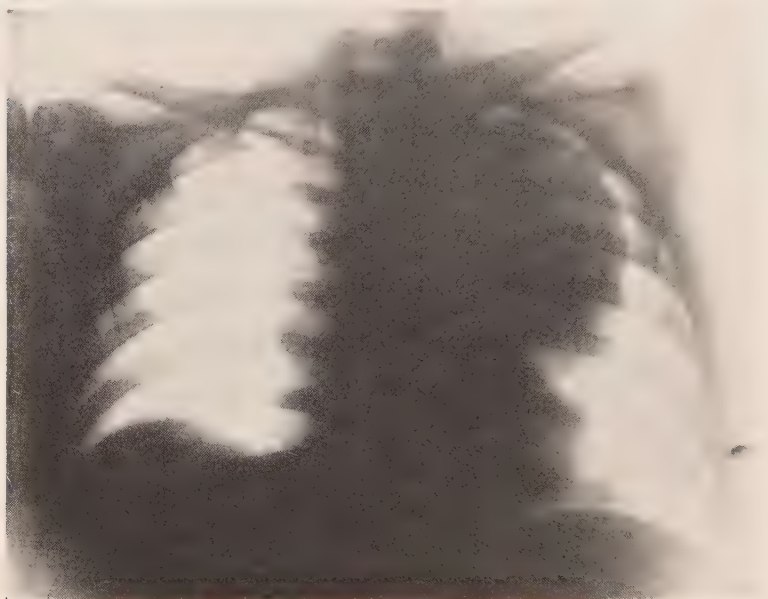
Large aneurysm of the arch of the aorta. Rupture, with instant death, occurred later, while the patient was in a physician's office. (Roentgenogram by Dr. G. C. Bird.)
